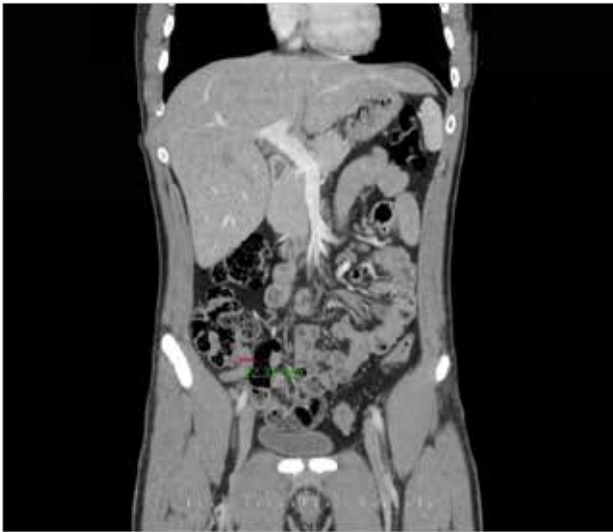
Acute appendicitis with computed tomography
